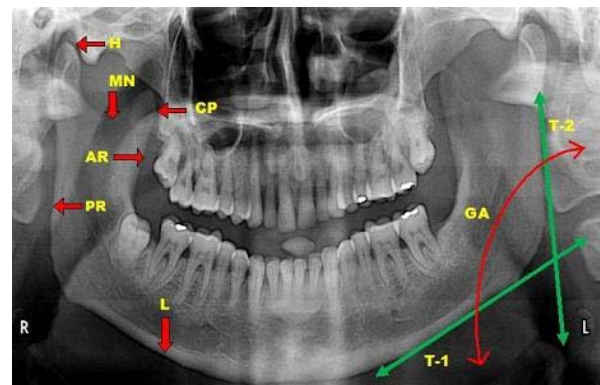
Orthopantomograph used in the study showing various anatomical landmarks of the mandible (on left side): L-Inferior border of mandible, PR-Posterior border of ramus, GA-Gonial angle/ mandibular angle, H-Head of mandible, AR-Anterior border of ramus, MN-Mandibular Notch, CP-Coronoid Process. The method of measuring Gonial Angle (GA) (Depicted on left side): T1 – Line tangent to the lower border of the mandible. T2 – Line tangent to the posterior border of ramus of the mandible. GA or Gonial Angle- The angle formed between T1 and T2.
